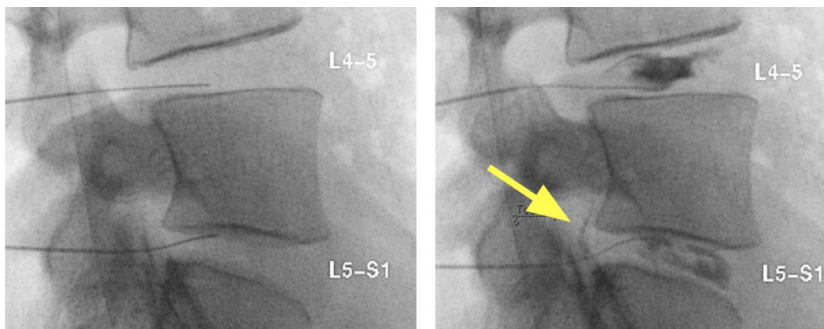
The fluoroscopic images on the left are the needles placed into the two lower discs(L4-5 and L5-S1) without contrast injection. The images on the right are after contrast injection (black fluid inside the disc).In a normal discogram the contrast should stay in the center of the disc (the nucleus pulposus) and not leak out (L4-5 is normal). If you look closely at the lower disc there is a faint black line of contrast (arrow) outlining the back of the disc that represents a tear of that disc (L5-S1). If the patient experiences similar pain to what they normally have (what is referred to as concordant pain) when we see that tear fill with contrast then that is an abnormal discogram. The discogram helps us confirm the diagnosis of what is referred to as internal disc disruption when the MRI is inconclusive. In our study patients were then randomized to receive either more contrast or LR-PRP.
